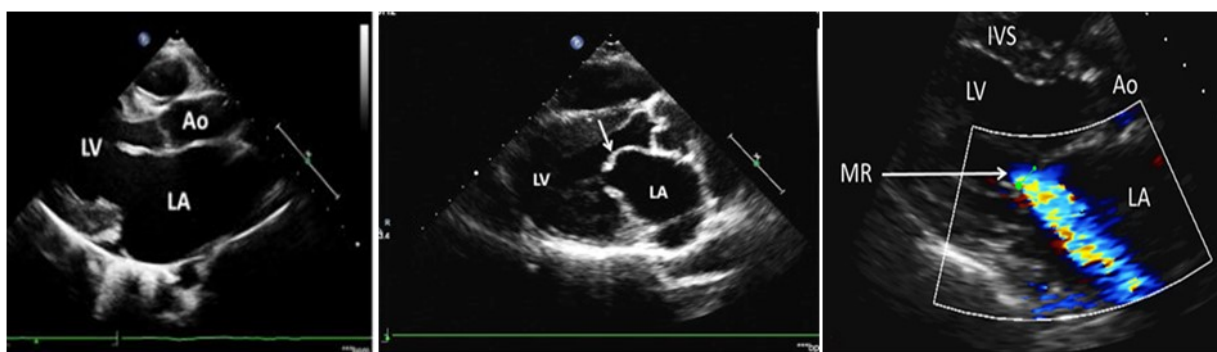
Parasternal View: Mitral valve thickened, clubbed, Sever mitral regurgitation
